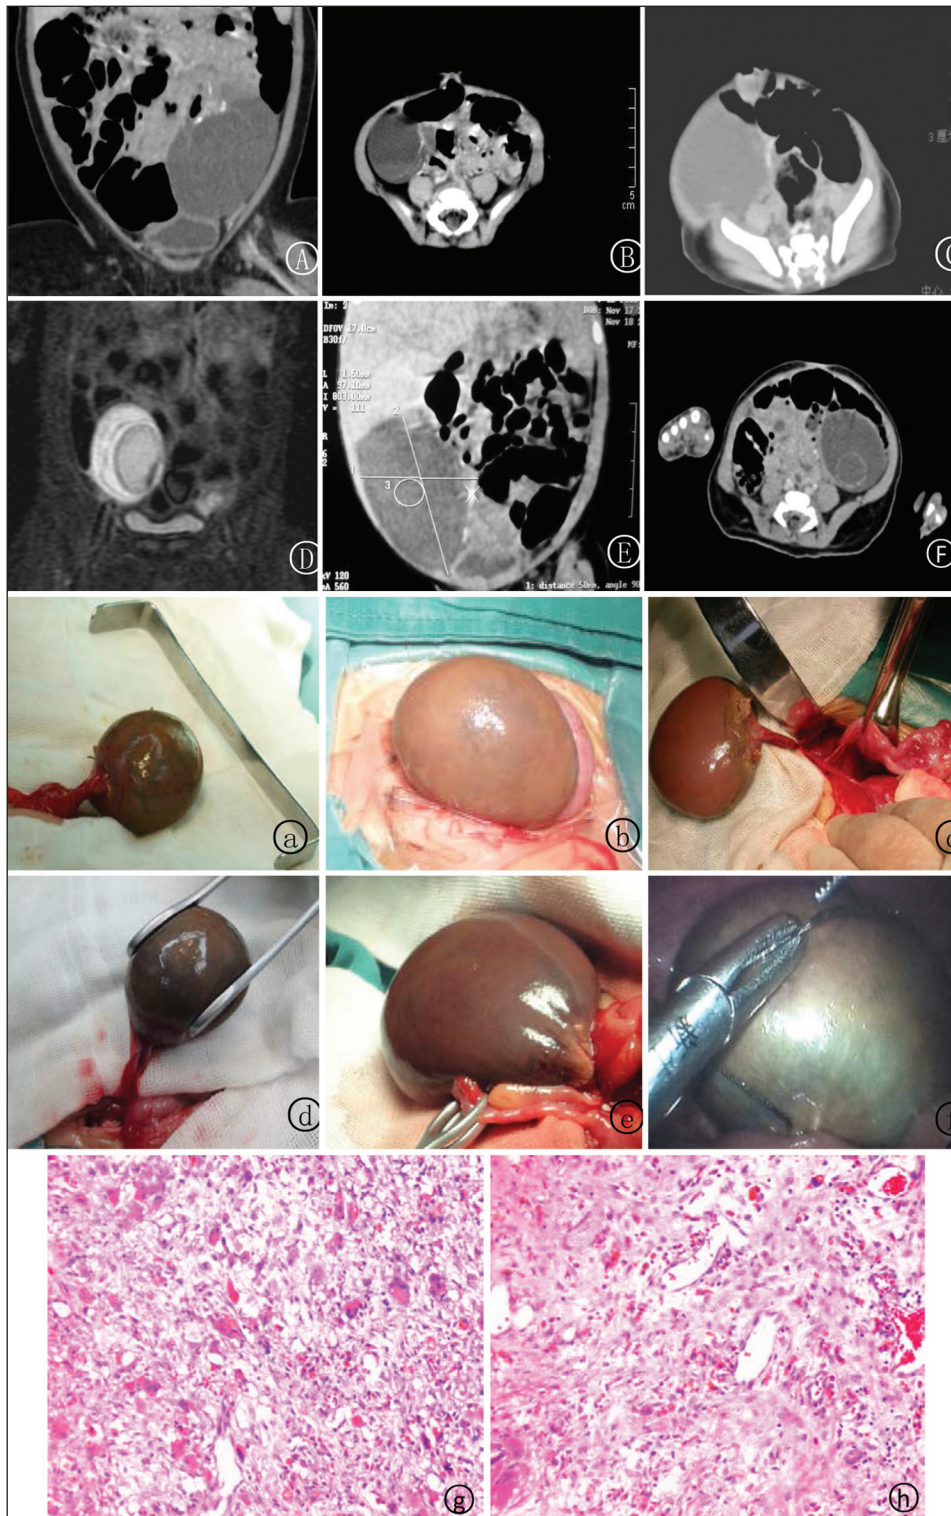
At the follow-up, no ovary was seen in the affected side in six cases. Preoperative MRI/CT indicated the following symptoms: Mixed ingredients in the cyst and hemorrhage (a), calcification (c, d, and f), a large number of sediments (b, d, and e), and separations in the cyst (d). This was a complicated cyst that should be distinguished from the intestinal duplication, mesenteric cyst, and teratoma. It is proved to be an ovarian cyst during the surgery. At an early stage, laparotomy and enucleation were conducted for the cases; at the late period, the surgery was performed by three-port laparoscopy technique in abdomen for the cases [Figure 1A-F]. The postoperative pathological result (2g and h) indicated ovarian cyst disease accompanied by obsolete hemorrhage, calcification, and granuloma
